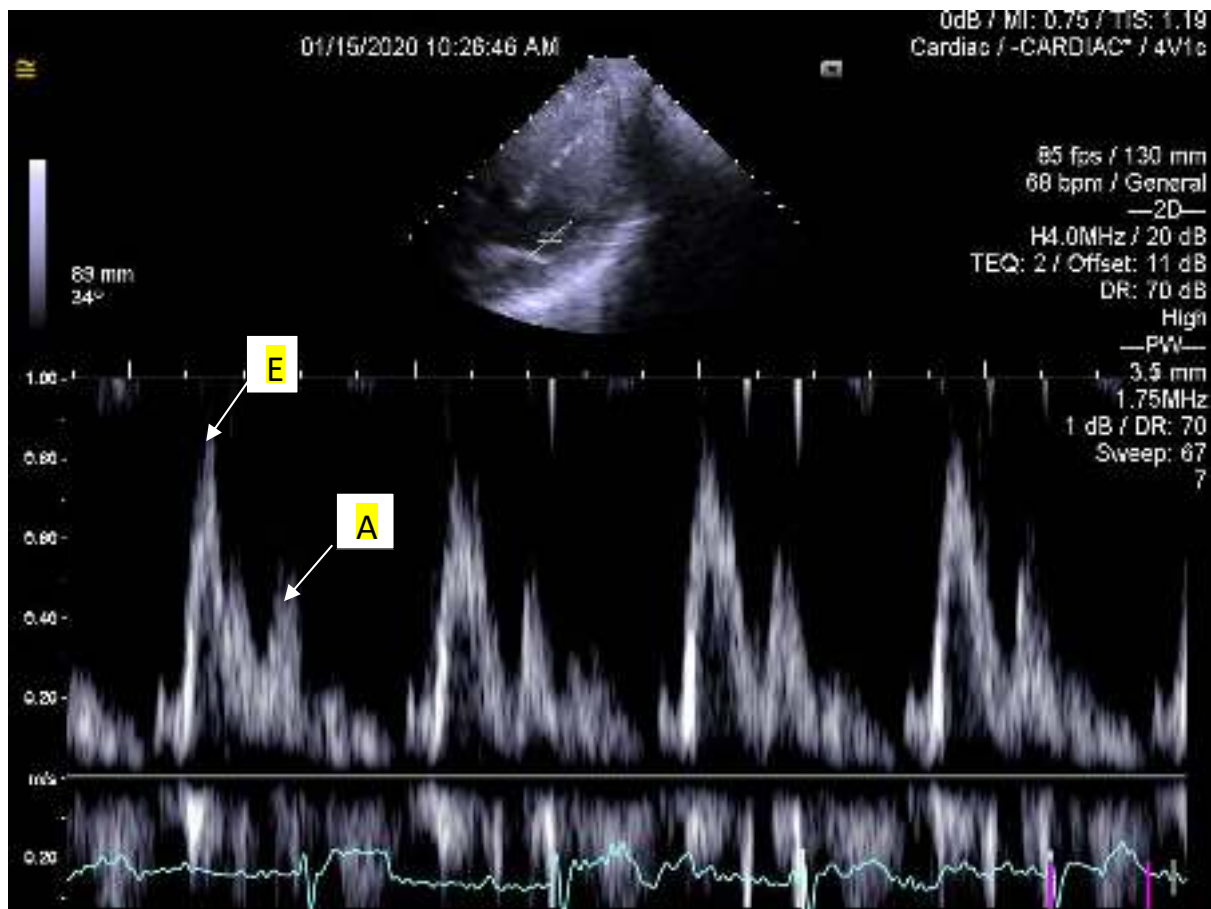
Mitral valve flow velocity using pulsed doppler through 2D guided echocardiography. E is early diastolic filling velocity; A is late diastolic filling velocity as a result of atrial contraction.
